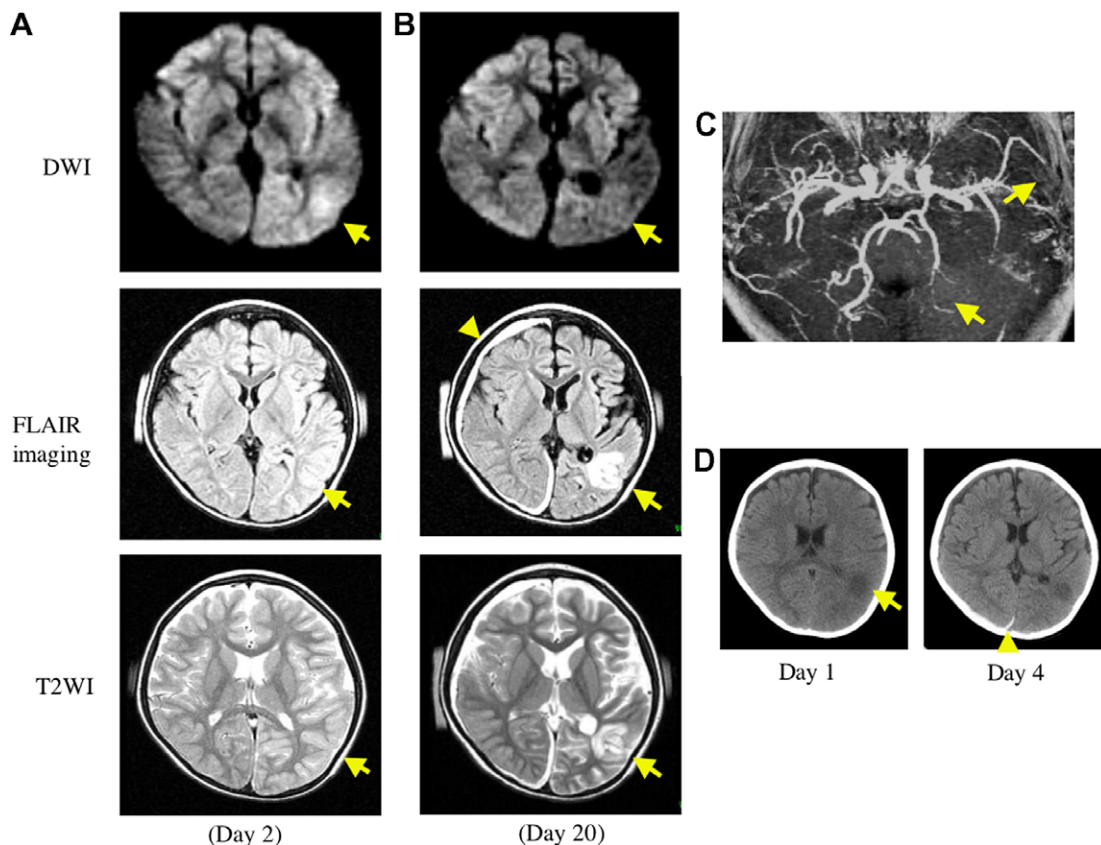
Serial MRI, CT, and MRA findings during the first stroke-like episode. MRI was obtained on days 2 (A) and 20 (B). Diffusion-weighted imaging (DWI), fluid-attenuation inversion recovery (FLAIR) imaging, and T2-weighted imaging (T2WI) showed mildly high signal intensity in the left temporo-occipital watershed area (arrows) on day 2 (A). On day 20, although the DWI showed reduced intensity in the corresponding lesion, FLAIR imaging and T2WI documented hyperintensity in the subcortical white matter involving the gray matter. In addition, a right-sided subdural hematoma (arrowhead) was seen on FLAIR imaging and T2WI. MRA showed occlusion of the distal middle cerebral artery (MCA) and left posterior cerebral artery (PCA) (C). CT on day 1 revealed a low-density lesion in the left temporo-parietal watershed area (arrow) (D, left) and on day 4 the right-side subdural hematoma (arrowhead) was seen (D, right).
